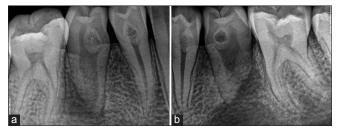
Preoperative intra-oral periapical radiographs. (a) Right mandibular premolars, (b) left mandibular premolars
